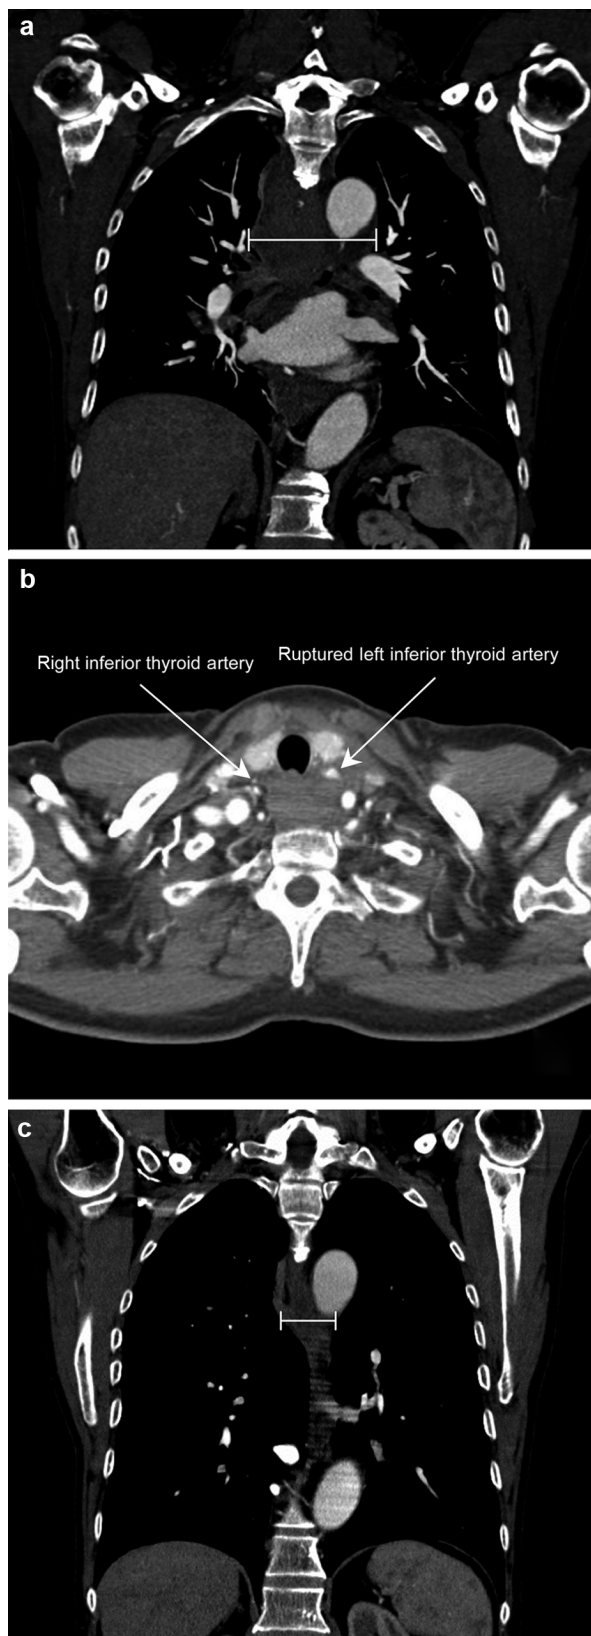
CT images of the mediastinal hematoma. Initially, a huge mediastinal hemorrhage filling up the whole retropharyngeal and retroesophageal space with a maximum diameter of 8.3 cm (a). The left inferior thyroid artery was identified as the originating structure (b). A control CT performed three weeks later showed a mainly resorbed hematoma with a remaining maximum diameter of 3 cm (c).
